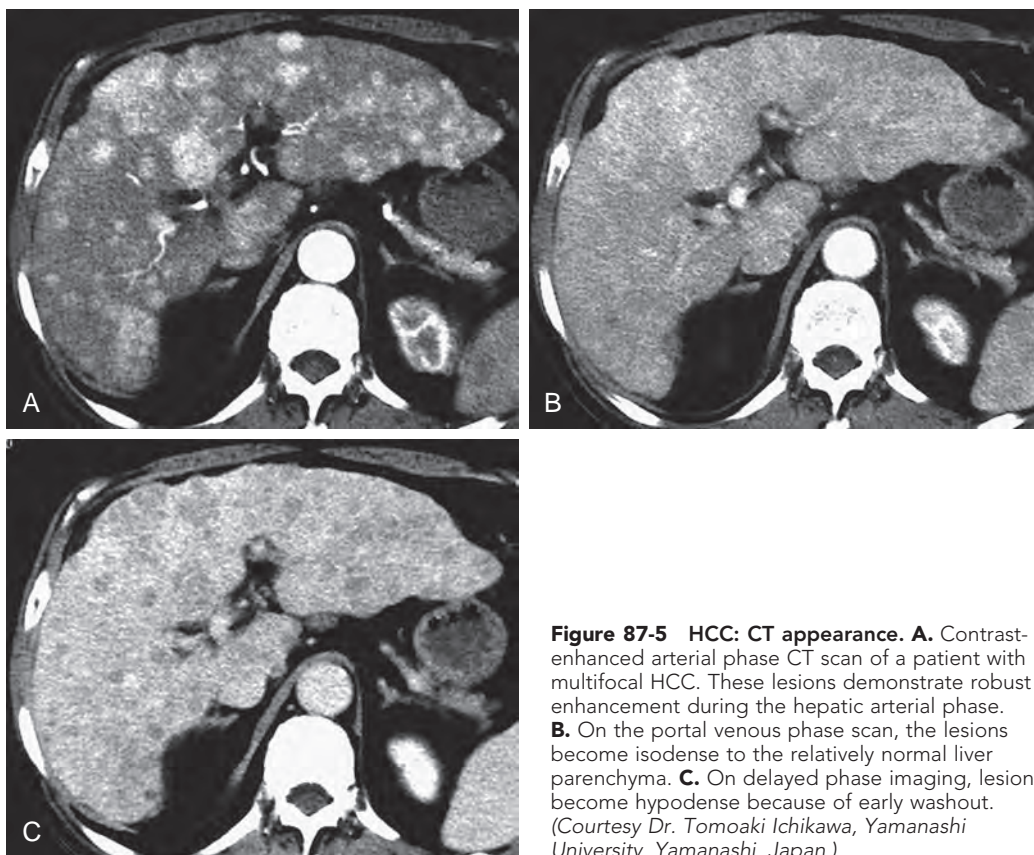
HCC: CT appearance. A. Contrast-enhanced arterial phase CT scan of a patient with multifocal HCC. These lesions demonstrate robust enhancement during the hepatic arterial phase. B. On the portal venous phase scan, the lesions become isodense to the relatively normal liver parenchyma. C. On delayed phase imaging, lesions become hypodense because of early washout. (Courtesy Dr. Tomoaki Ichikawa, Yamanashi University, Yamanashi, Japan.)
